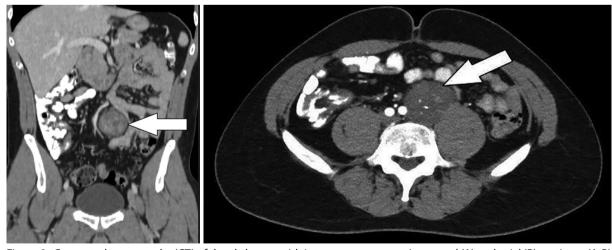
Computed tomography (CT) of the abdomen with intravenous contrast in coronal (A) and axial (B) sections. (A-B) A well-circumscribed mass with heterogeneous contrast enhancement, located anterior to the L4 vertebra, abutting the left ureter and left common iliac artery.
